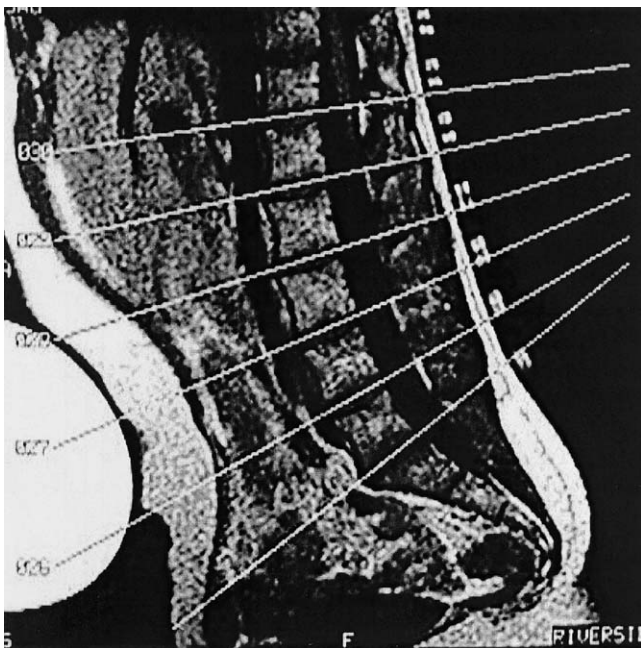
Sagittal magnetic resonance imaging scan of torso in 15-degree flexion, showing the scan lines for the axial slices through and parallel to the intervertebral discs.
